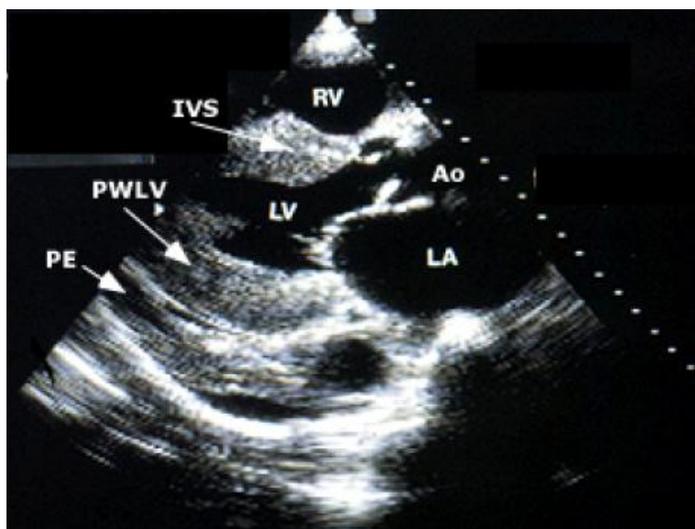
Parasternal Long axis view of 2-D echo of patient's heart. Septal (IVS) shows significant hypertrophy. Posterior left ventricle wall also shows slight hypertrophy. Wall thickness shown to be ~12mm in left ventricle.
